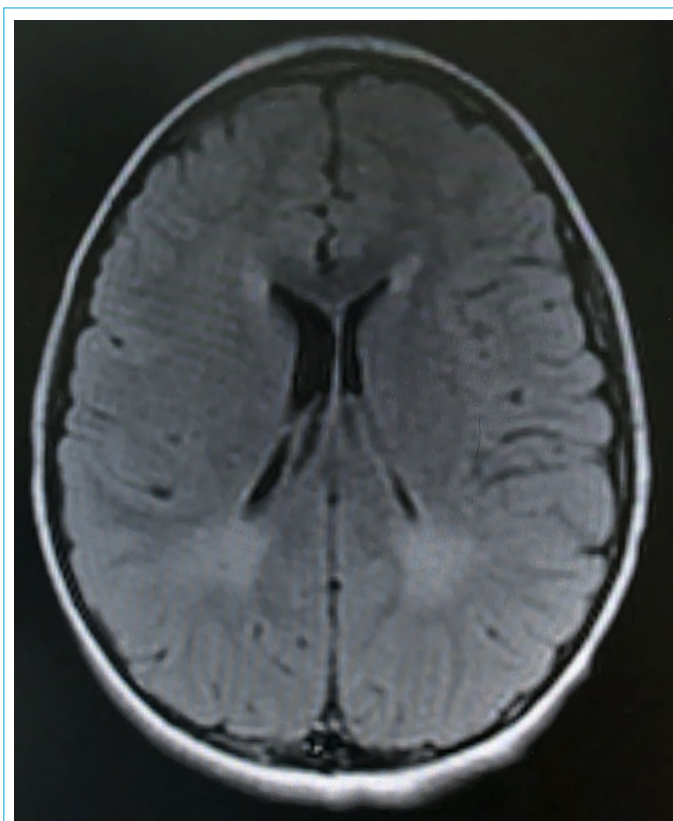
Axial T2-FLAIR brain MRI of a patient with moderate PKU, showing mild gliotic white matter changes in the bilateral periventricular peritrigonal regions, more prominent posteriorly.
